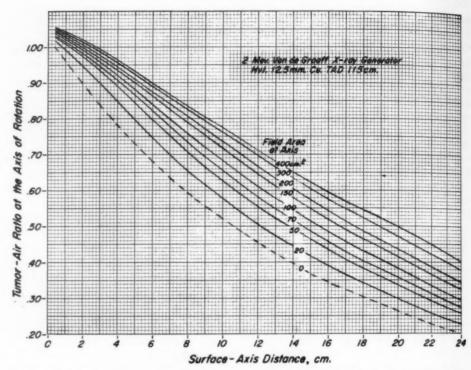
Variations of tumor-air ratio with thickness of overlapping tissue at different field areas for the Van de Graaff x-ray generator.
